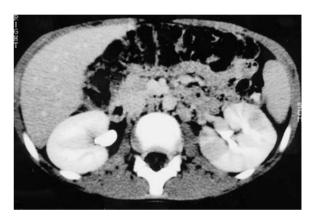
APN and CT. Contrast-enhanced CT: triangularshaped areas of decreased enhancement corresponding to the diseased parenchyma
